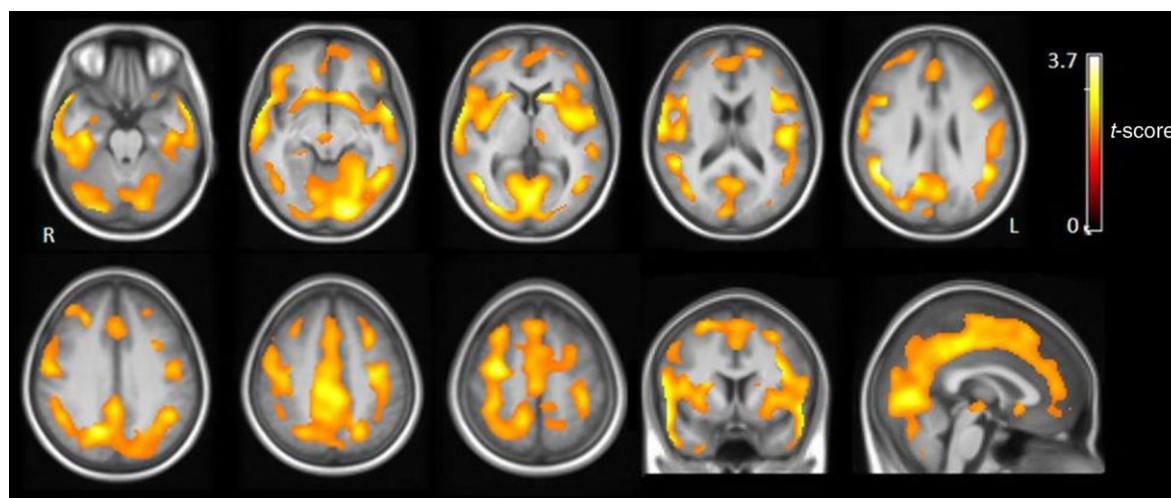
Statistical parametric mapping (SPM) results of the absolute decrease in CB₁ receptor availability in chronic cannabis users compared with controls in transverse, coronal and sagittal sections overlaid on a T1-weighted magnetic resonance imaging template ($P_{\text{height}} < 0.005$ uncorrected, $K_{\text{ext}} > 50$). The colour bar expresses t -score levels
